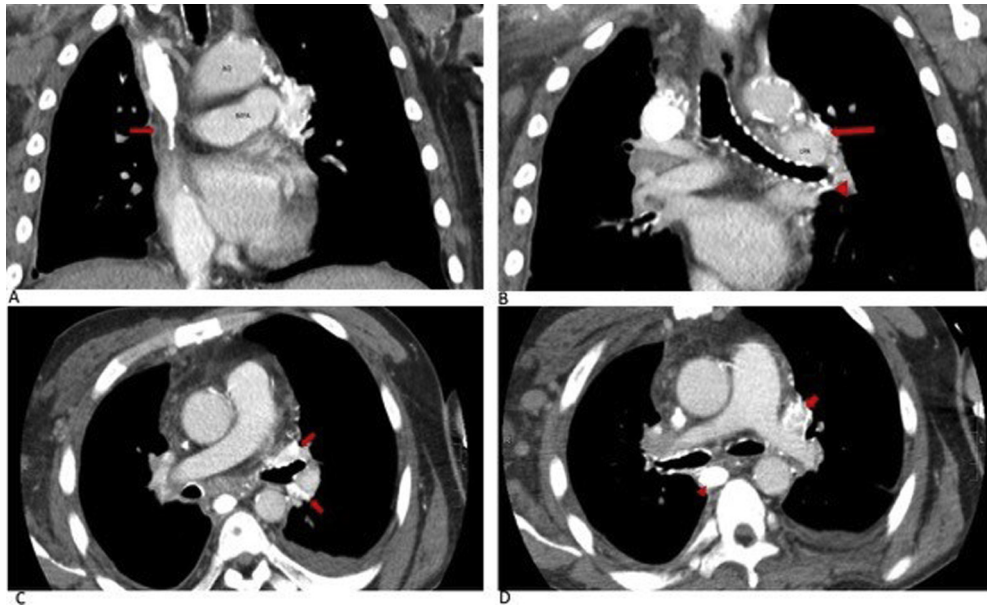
Systemic-to-pulmonary collateral vessels in a 30-year-old man with a history of end-stage renal disease and multiple dialysis catheter placement. He underwent chest computed tomography with contrast to evaluate the venous system given inconsistent findings on contrast echocardiography. (A) Coronal image showing narrowing of the distal SVC. (B) Coronal computed tomographic image shows systemic-to-pulmonary collateral vessels (*arrow*) surrounding the left pulmonary artery, with contrast visible in the left superior pulmonary vein (*arrowhead*). (C) Axial computed tomographic image showing collateral vessels around the left main stem bronchus (*arrow*). (D) This is also seen around the left pulmonary artery (*arrow*), along with dilation of the azygos vein (*arrowhead*). Dilation of azygos system along with nexus of collateral blood vessels throughout the bronchopulmonary trunk suggests involvement of the bronchial venous system in this right-to-left shunt.
